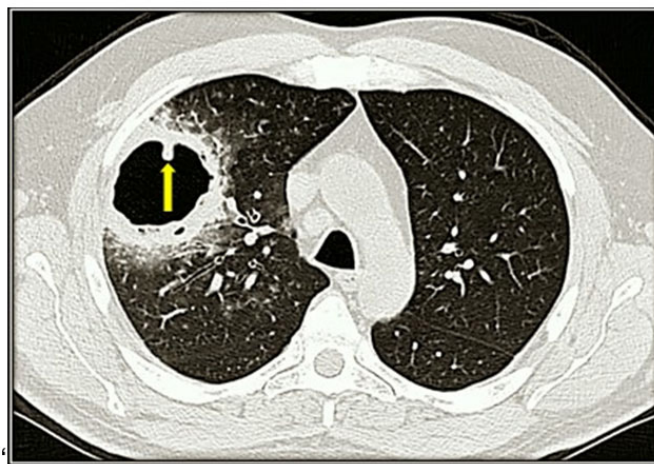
CT scan showing a huge (maximal diameter: 6.5 cm) mycetoma in the upper lobe of the right lung.
